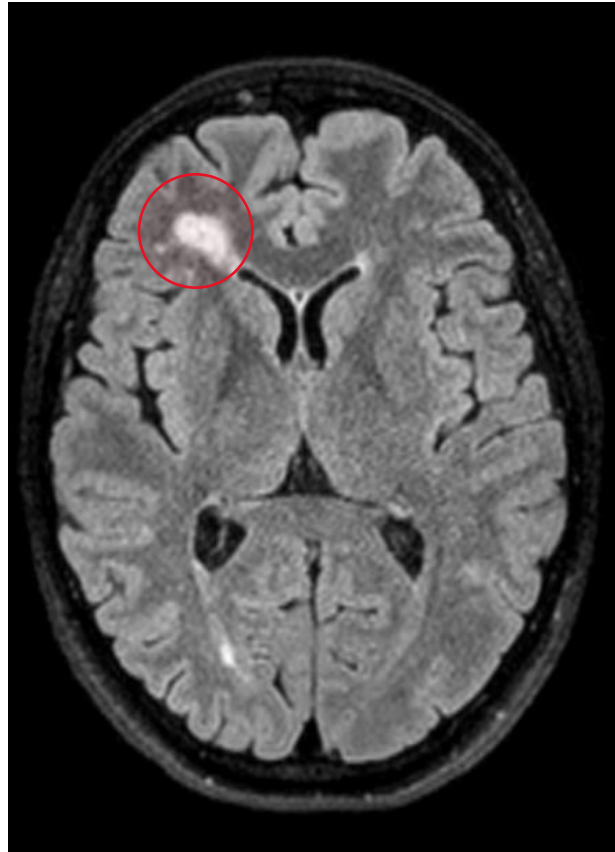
Axial FLAIR image for MS lesion (Jenin Governmental Hospital).
